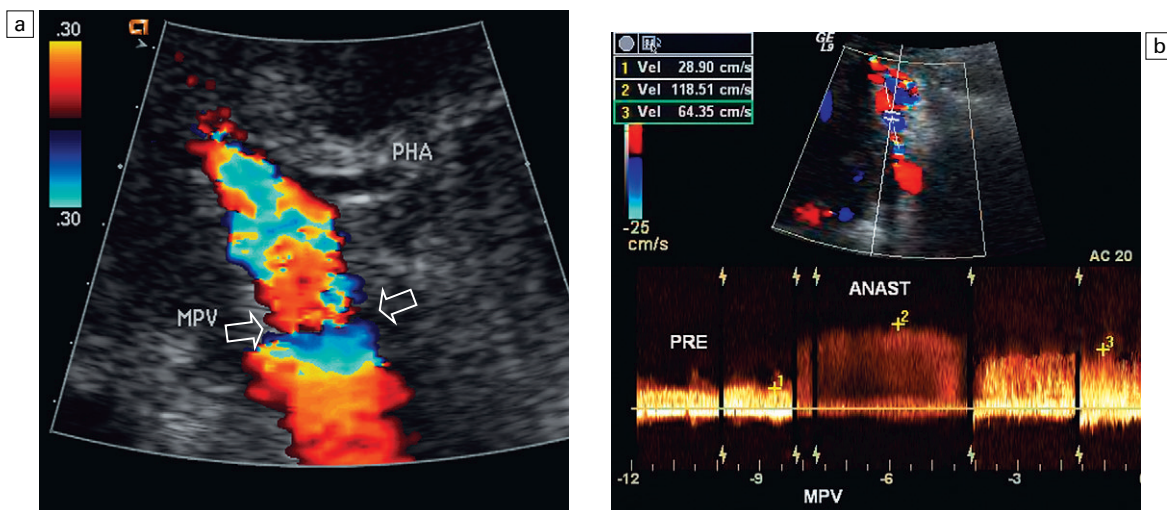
Colour Doppler image of the porta hepatis (a). The anastomosis between donor and recipient portal vein is evident by the change in calibre which causes the focal aliasing at that level (arrows). Spectral Doppler tracing (b) across the anastomosis and on either side reveals the velocity changes are relatively insignificant in this normal anastomosis.
